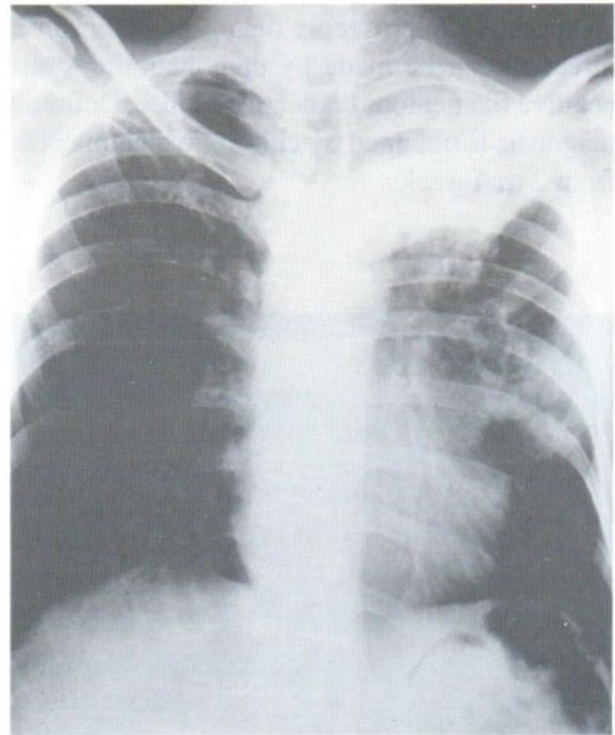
Chest radiograph shows patchy infiltrate with cavities in the left upper lobe.
